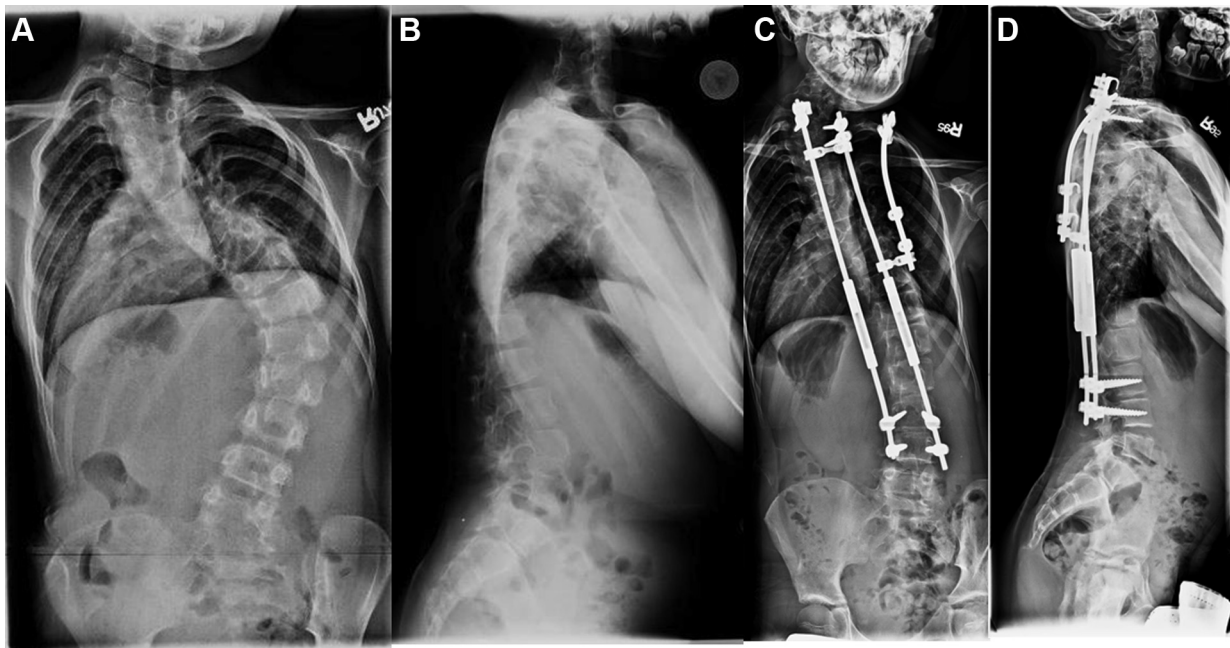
Seven-year-old girl with Goldenhar syndrome. (A) Preoperative anteroposterior radiograph demonstrates 87° scoliosis. (B) Preoperative lateral radiograph. (C) Two-year postimplantation of rib-based distraction device demonstrates that T1–S1 height has increased from 28.3 cm postimplantation to 30.6 cm at two-year follow-up. (D) Two-year postimplantation lateral radiograph.
